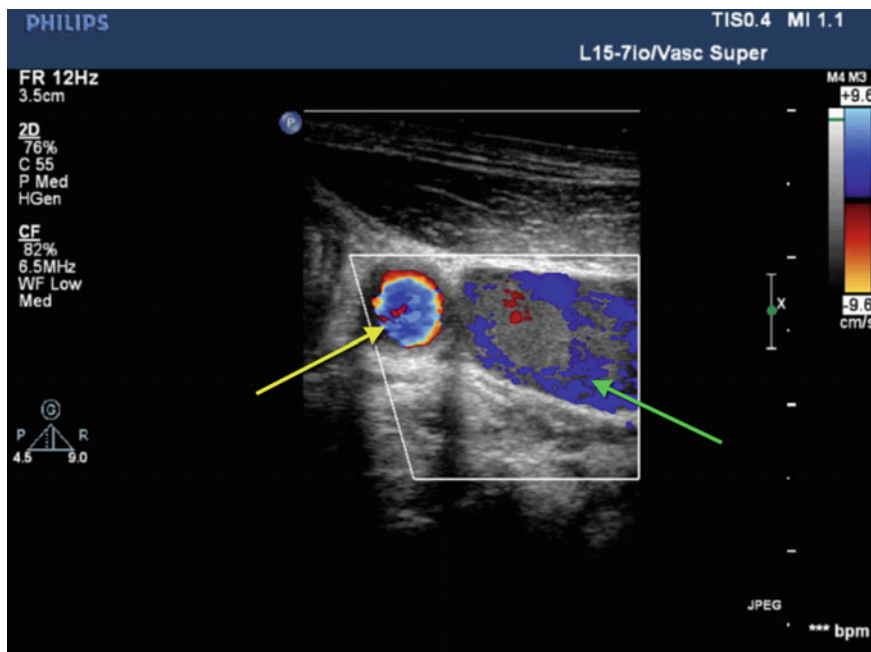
Out of plane imaging (SAX view) of the right internal jugular vein (*green arrow*) with color flow Doppler. *Yellow arrow* indicates the carotid artery. Color flow Doppler imaging demonstrates faster pulsatile laminar flow in the carotid artery with slower flow in the jugular vein
